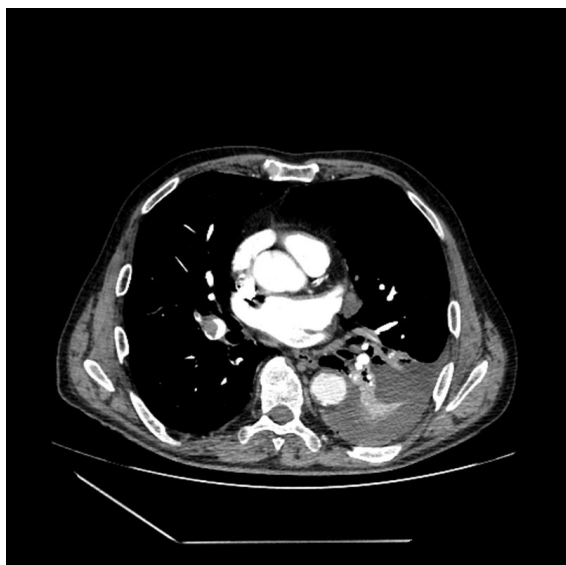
Chest CT angiography: pulmonary embolism, left-sided pleural effusion and left-sided atelectasis
